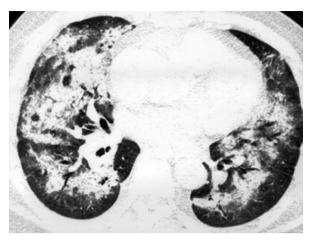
Computed tomography of the chest revealed bilateral consolidations with peri-bronchovascular bundle distribution.
